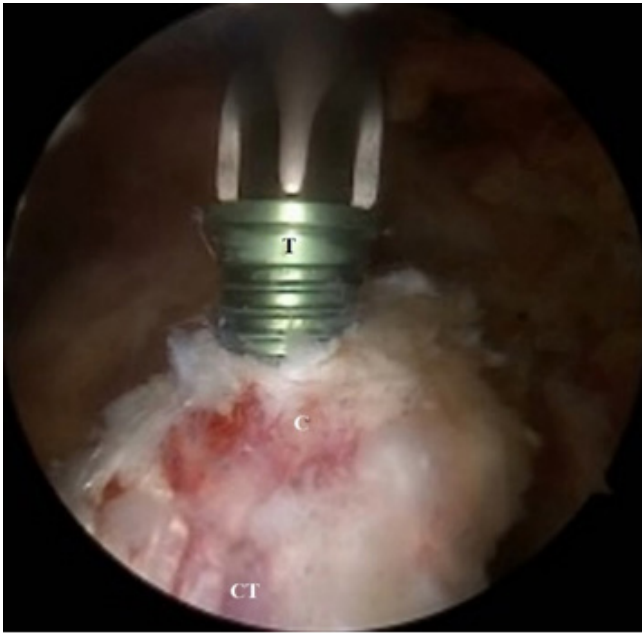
Exposure of the coracoid process (viewing portal: inferior, working portal: lateral and medial, right shoulder). The coracoacromial ligament and pectoralis minor tendon were released from the lateral and medial side of the coracoid process, respectively. Then two top hats were inserted in the coracoid holes after making holes in appropriate positions using the guide. T: top hat, C: coracoid process, CT: conjoined tendon.
